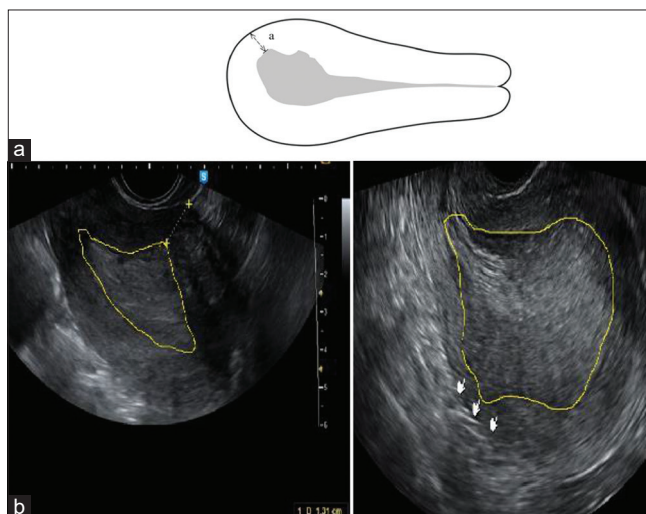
(a) Sagittal view of the uterus: The shortest myometrial tumor-free distance (TFD) to the serosa, which is a measure of the distance between maximal myometrial invasion and the uterine serosa, measured in cm. This will be the objective measurement in assessing myometrial invasion. A TFD ≤ 0.8 cm will signify deep myometrial invasion or $\geq 50\%$ myometrial invasion, (b) Ultrasound image measuring TFD at the site of deepest tumor invasion
